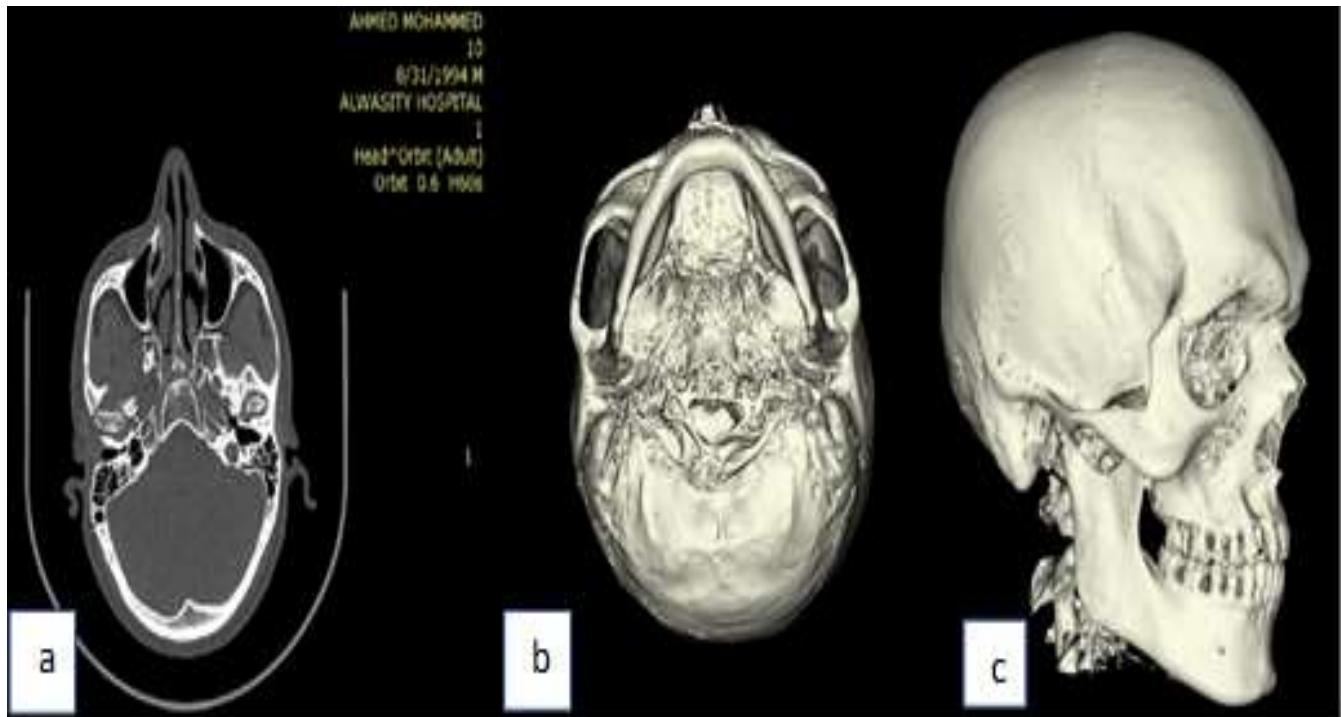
A: Axial view. B: 3D inferior view. C: 3D lateral view. 3 months postoperatively CT scan reveal bone healing at the fracture site and accurate right-side zygomatic arch reduction.
